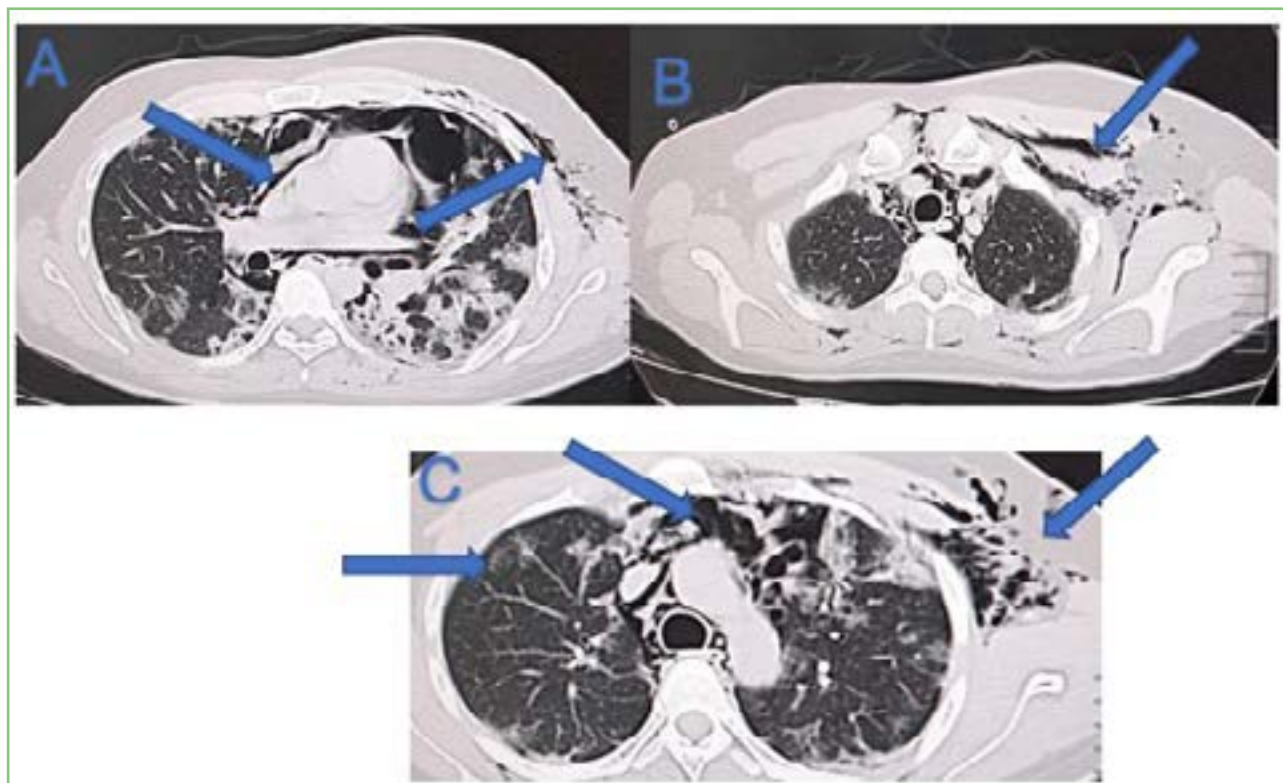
RBCM. A: Computed Axial Tomography of the chest at 15 days postcovid which shows pneumomediastinum and subcutaneous emphysema. B: Chest CT showing the magnitude of the subcutaneous emphysema C: Chest CT showing consolidation, pneumomediastinum as well as subcutaneous emphysema.
